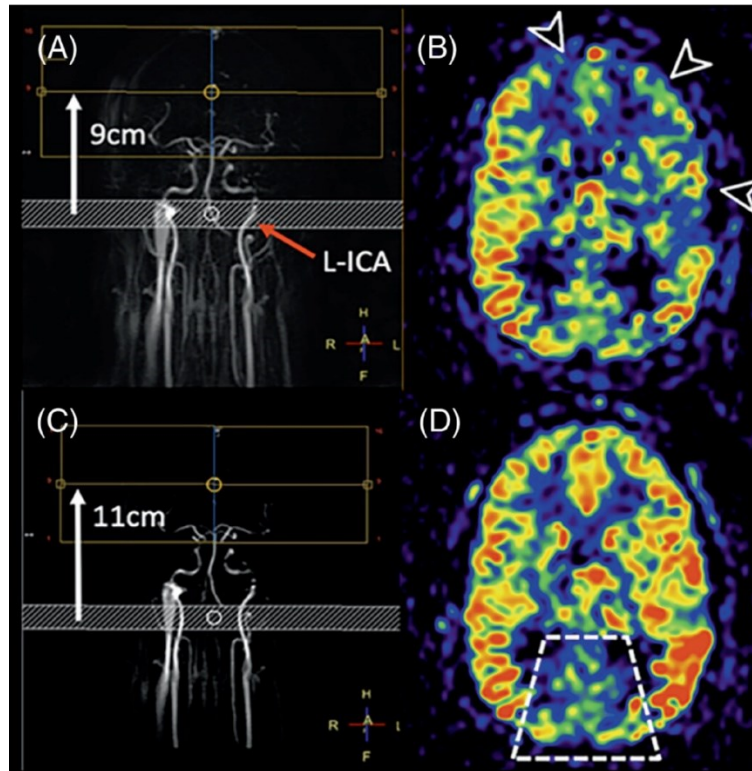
(taken from Lindner et al., “Current state and guidance on arterial spin labelling perfusion MRI in clinical neuroimaging” (Linder 2023)). In B) there is apparent hypoperfusion of the left middle cerebral artery and bilateral anterior cerebral artery territories, considered to be due to inefficient labelling secondary to the oblique orientation of the left internal cerebral artery through the labelling plane on the planning angiogram in A). In C), the labelling plane has been moved caudally and subsequently D) demonstrates more uniform cortical perfusion. The dashed box in D) demonstrates pseudo-hypoperfusion of the posterior circulation due to inefficient labelling of the vertebral arteries, which demonstrate a tortuous course through the labelling plane in C).
